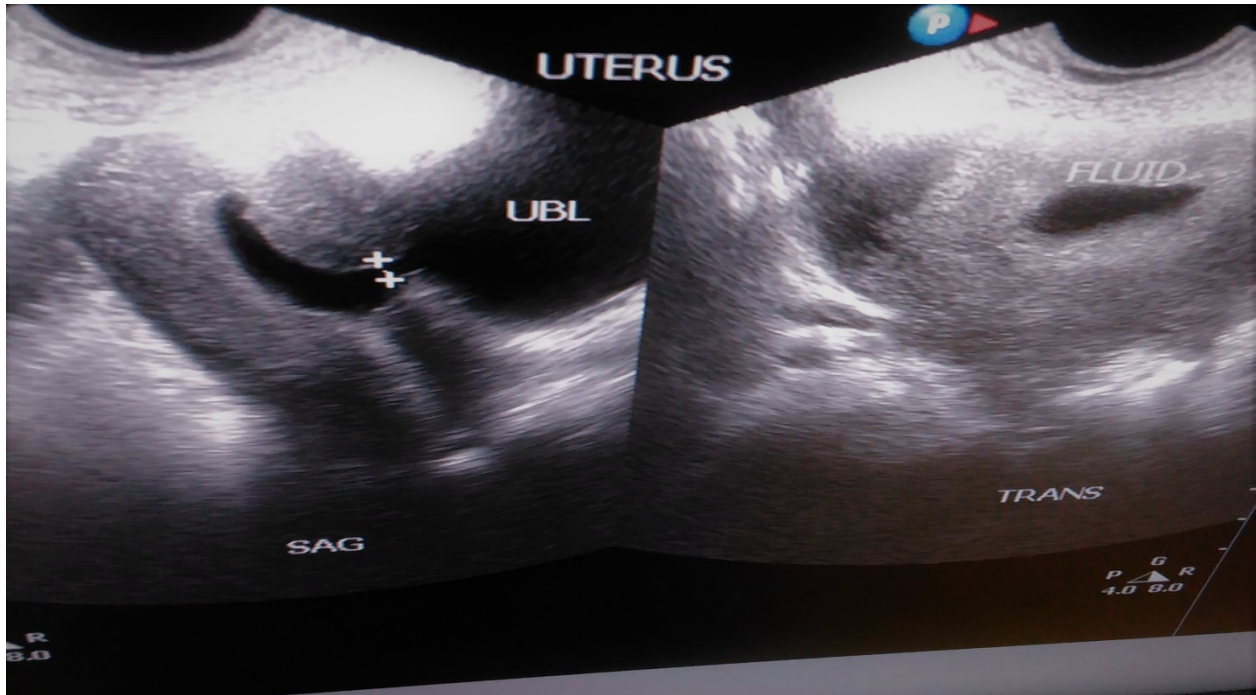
The sonogram showing the above findings
